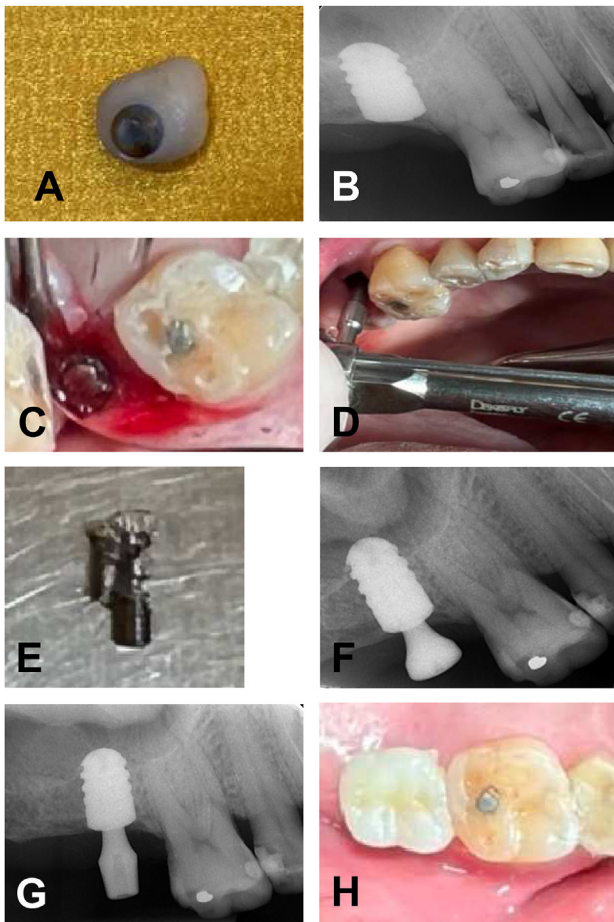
Clinical and radiographic photographs of our case. (A) The detached crown of the right maxillary second molar from the dental implant. (B) Radiographic photograph revealing a root-form cylindrical implant replacing the right maxillary second molar. (C) Clinical photograph showing a dental implant with a fractured abutment screw within the implant body. (D and E) The dentist used a straight fissure bur to carefully create a groove of sufficient depth on the fractured screw surface and then used a counter-torque screw-retrieval device to remove the taper fractured screw fragment from the implant with a counterclockwise screwing action. (F) Subsequently, a healing abutment was screwed into the original implant to let the tissue heal. (G) Radiographic photograph exhibiting a new abutment screw in the original implant for an impression to fabricate a new prosthesis. (H) Clinical photograph showing a zero-degree cusped crown cemented to the abutment of the original implant.
